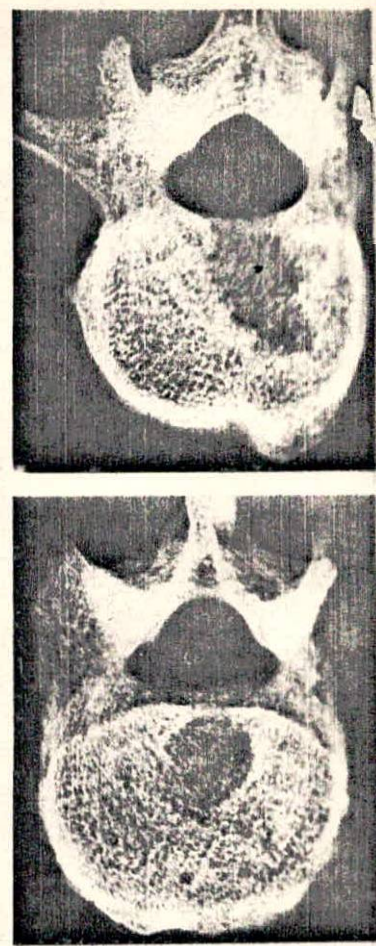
Case 2. Superoinferior roentgenogram of L-3 (top) and L-4 (bottom).
